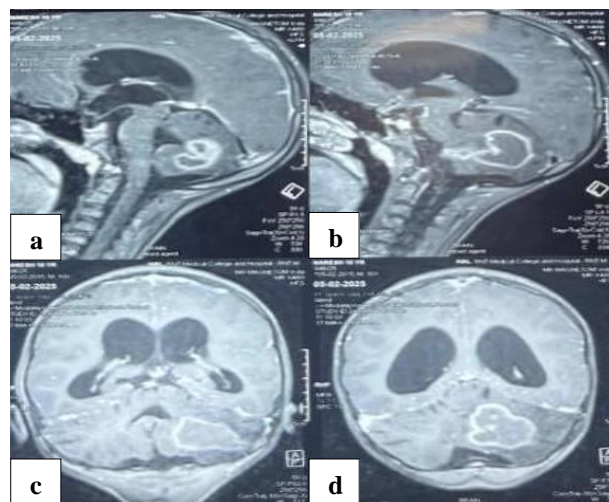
(a-d): CE MRI showing cerebellar abscess.
